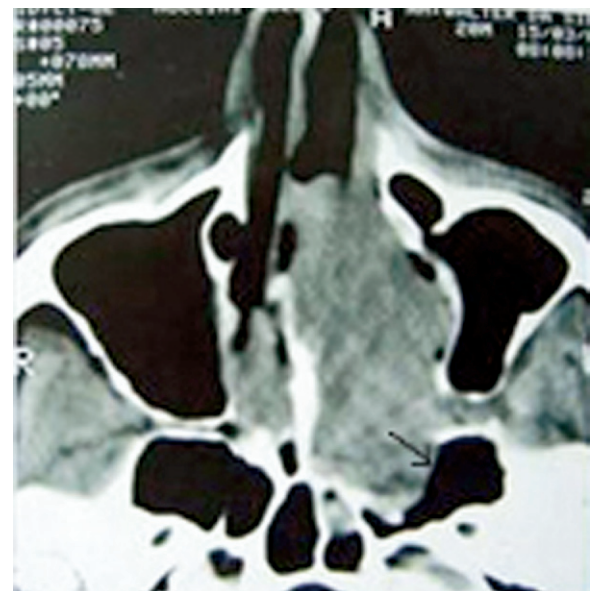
Axial CT scan showing an angiofibroma in the nose and pterygopalatine fossa.
